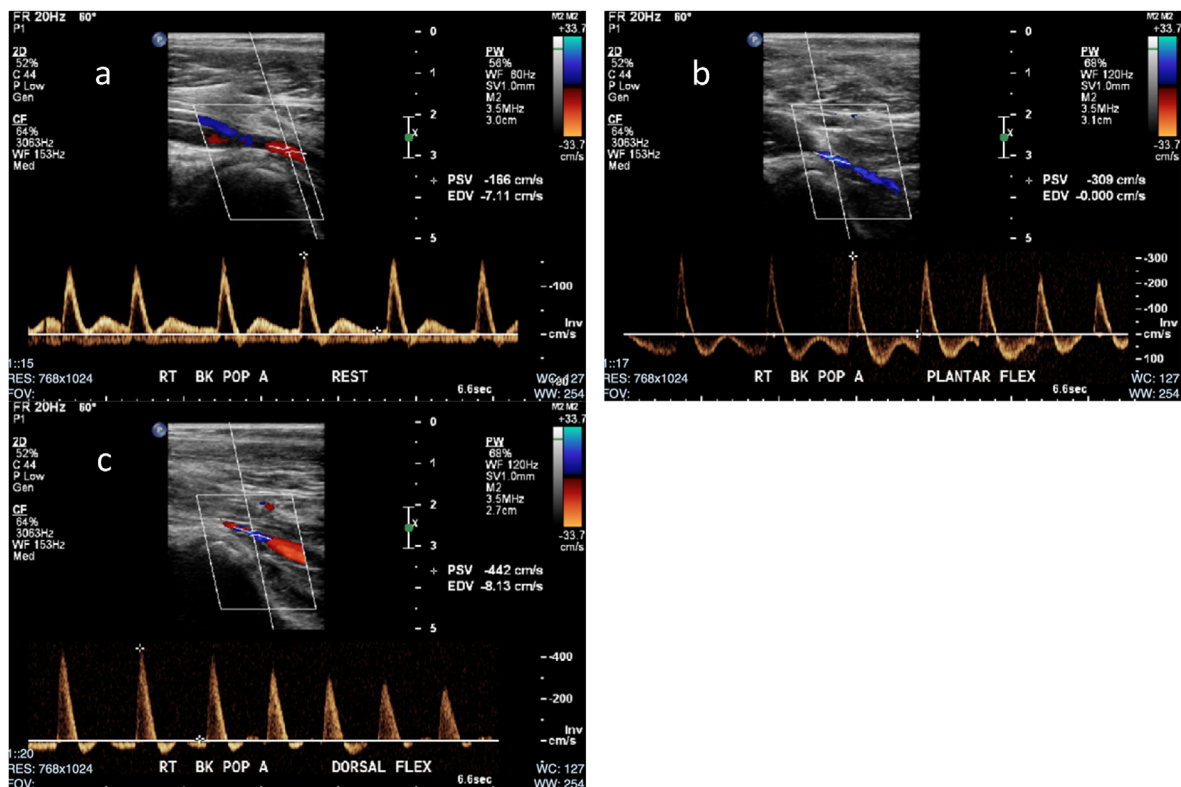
Duplex Doppler Ultrasound images of the right below-knee popliteal artery at rest (image a) and with plantar (image b) and dorsiflexion (image c). Compression leading to elevated peak systolic velocity (PSV) is seen in plantar and dorsiflexion with associated disturbed flow.
